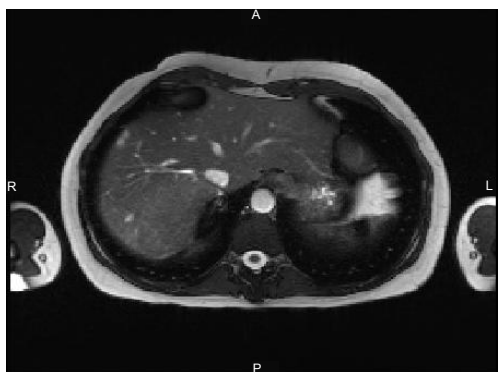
MRI T2, IVC of normal caliber above the level of the tumour.
